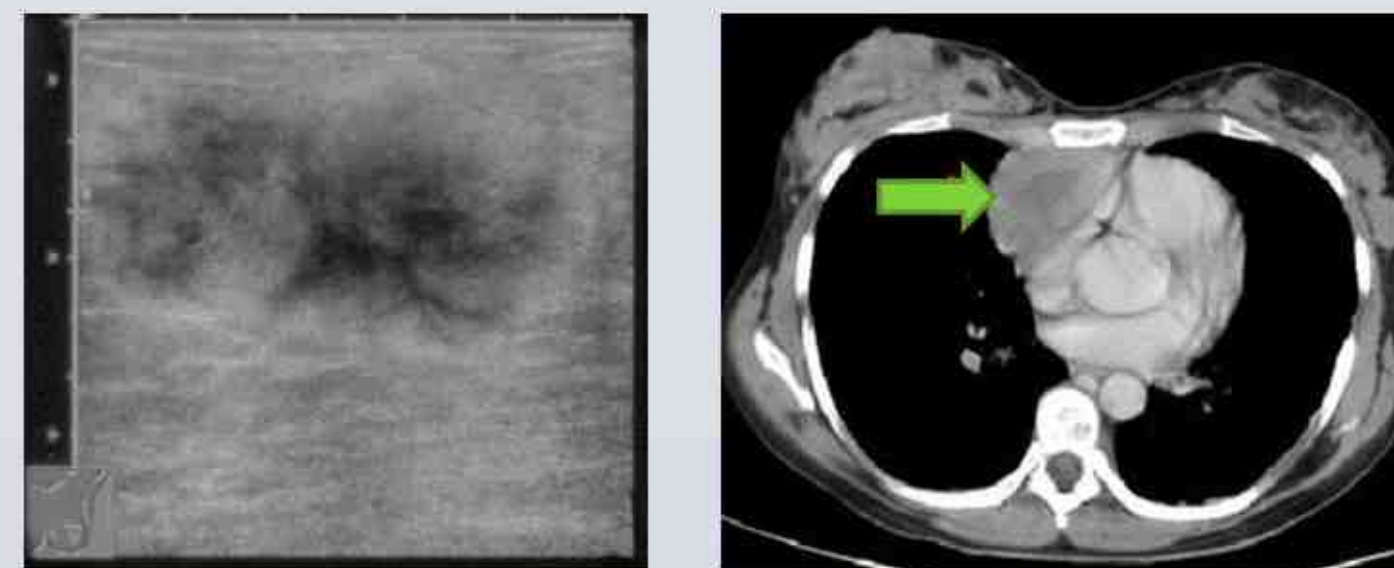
(far left) US showing an ill defined hypoechoic mass found to be lymphoma. Fig 10. (left) Axial CT of the same patient showing a right anterior mediastinal nodal mass.
